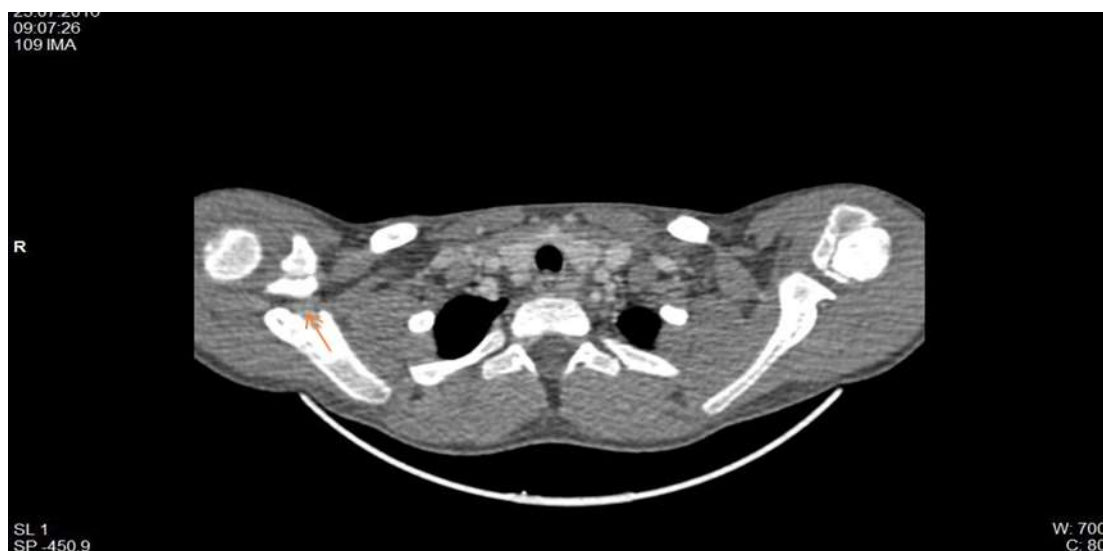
CT scan, right IJV thrombosis (red arrow) (personal collection Nephrology Department).
